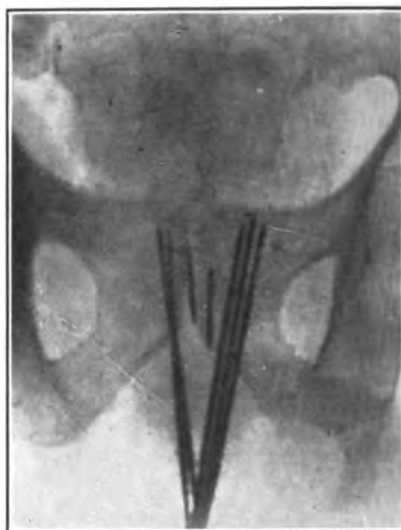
Radiograph of radium needles inserted through the perineum into a malignant prostate
